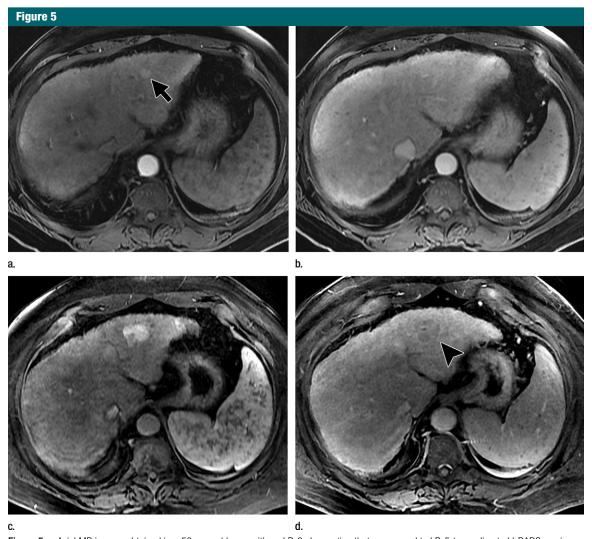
Axial MR images obtained in a 56-year-old man with an LR-3 observation that progressed to LR-5 (according to LI-RADS version 2014). (a) Arterial phase image acquired after administration of gadobenate dimeglumine shows a small (13-mm) nodular hyperenhancing observation in the left lobe (arrow). (b) Observation shows an isointensity in the portal venous phase that is occult on images obtained with other sequences (not shown). (c) Nineteen months later without any interim follow-up examinations, the observation has grown to 33 mm in diameter, continues to show arterial phase hyperenhancement, and (d) now shows partial hypointensity (arrowhead) relative to liver parenchyma in the portal venous phase. Due to the combination of imaging features (diameter ≥ 20 mm, arterial phase hyperenhancement, partial washout appearance, and threshold growth), the observation now is categorized as LR-5. Notice that at 19 months, the mass has become heterogeneous, with some areas enhancing more than others.
